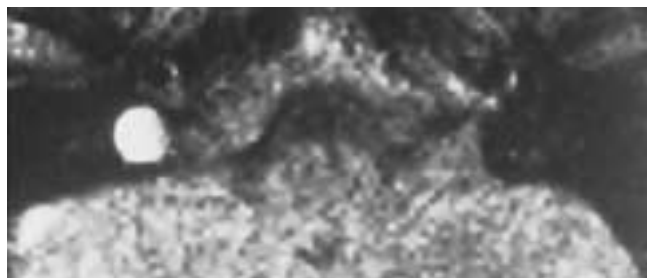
High jugular bulb. T2-weighted image. Flow-related enhancement must not be mistaken for a jugular foramen tumor. Note the smooth, perfectly rounded outline of hyperintensity filling the jugular bulb.
